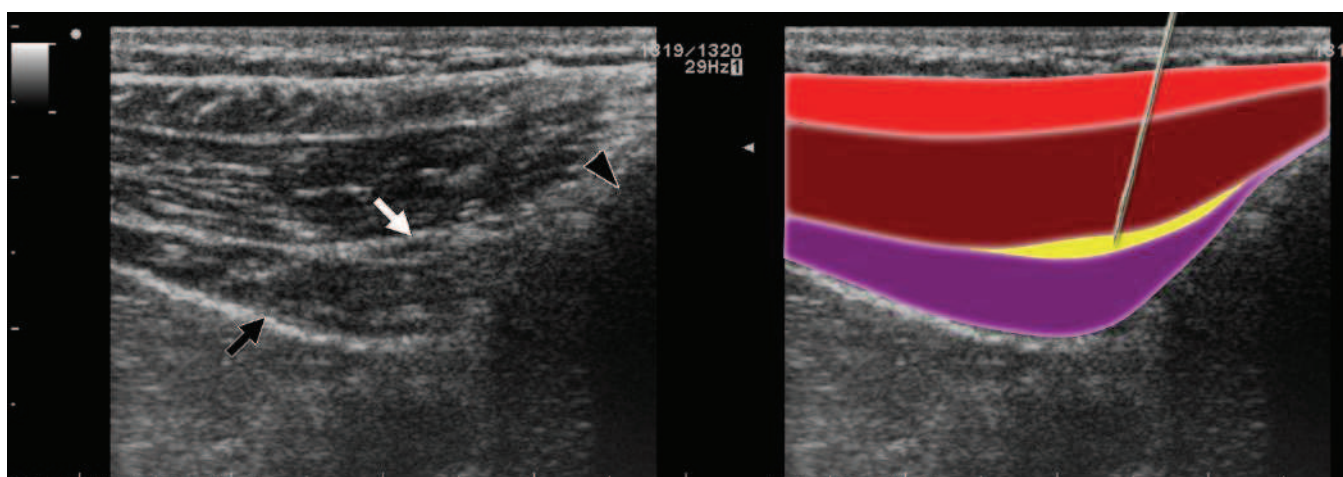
Ultrasound picture taken at level of anterior superior iliac spine (black arrow head) showing the 3 layers of abdominal wall .
